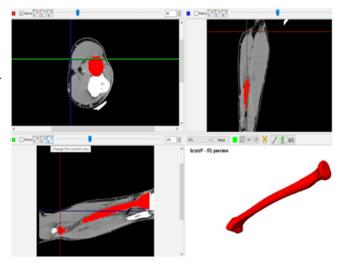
Figure I Reconstruction of bone into a numerical model from a CT.
